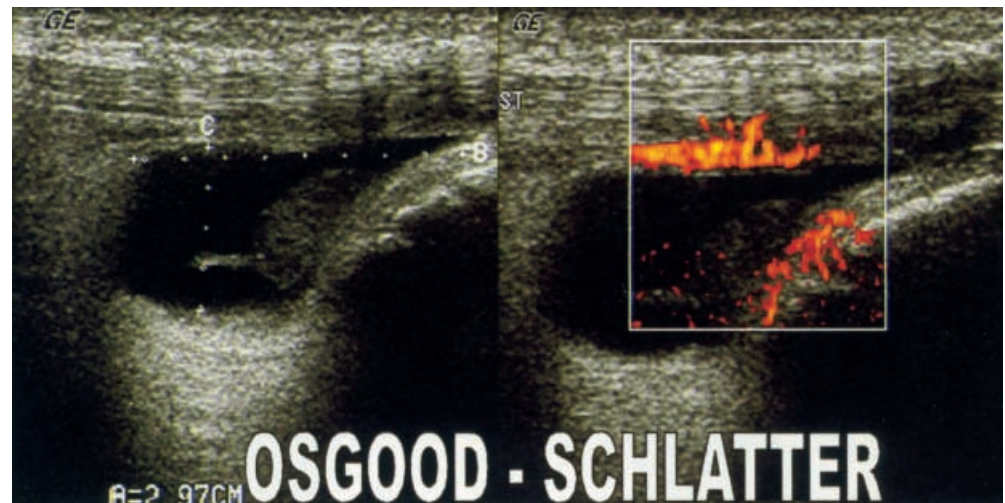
Osgood-Schlatter disease. Ultrasound documents abnormal distension of the deep infrapatellar bursa (*left*) as well as abnormal power Doppler flow (*right, arrow*)
